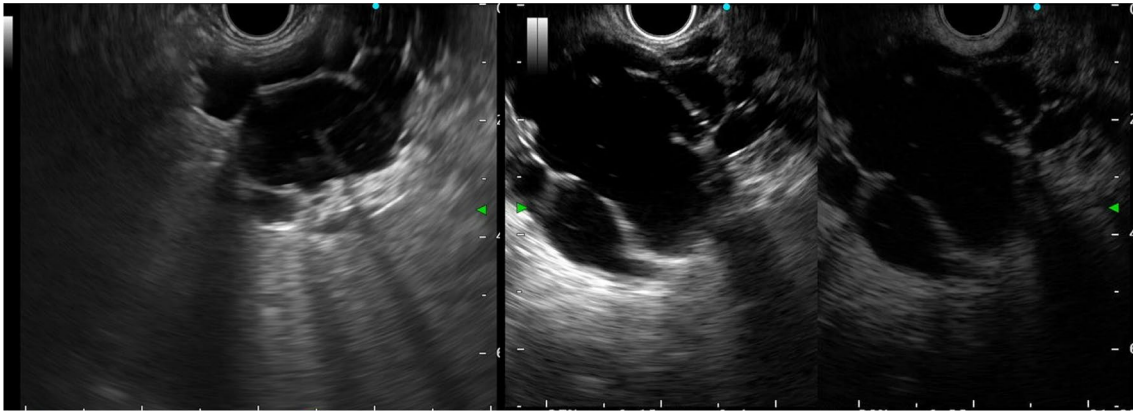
Endoscopic ultrasound (EUS) revealed a multi-sized, multifocal cyst of approximately 50 mm in the pancreatic tail. The septal wall did not display any thickening, and the cysts varied in size. Furthermore, there was no main pancreatic duct communication or dilation
